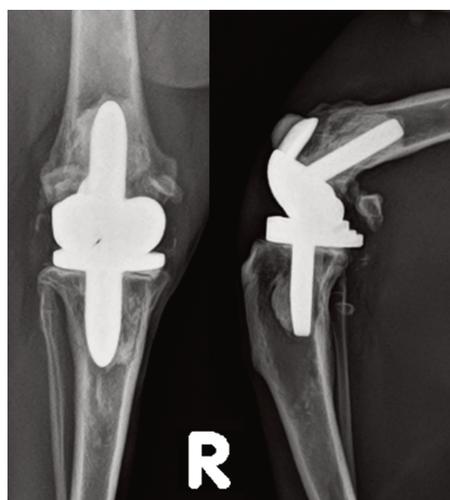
Radiographs 8 weeks after surgery, in anteroposterior (left) and mediolateral view (right)
